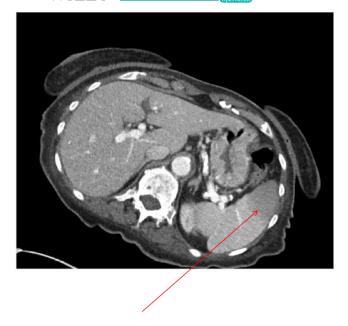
Axial view of CT Abdomen with appearances consistent with splenic infarcts
